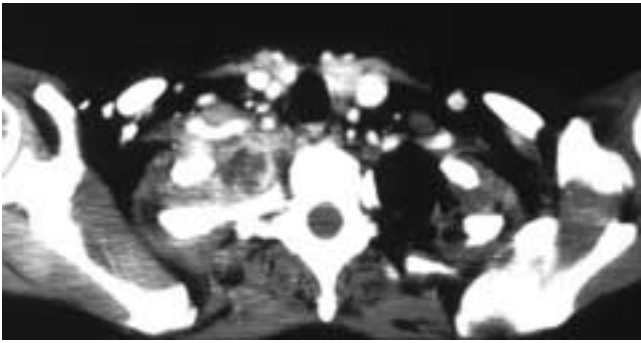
Pancoast tumor. Contrast-enhanced CT scan shows a necrotic mass with heterogeneous enhancement in the right lung apex. This mass involves the right chest wall between the first and second thoracic vertebrae and extends to the posterior branches of the subclavian artery. The inferior trunk of the brachial plexus is located posterior to the subclavian artery.
